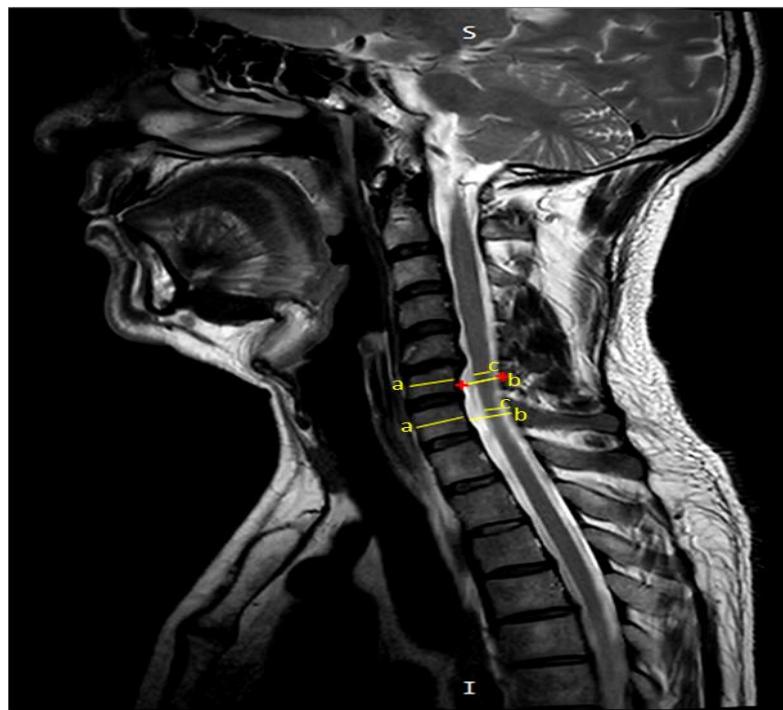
Mid-sagittal T2 weighted MRI image of cervical spine in a 49 year male patient, Sagittal-diameter measurements of the spinal cord, spinal canal, and vertebral body.
